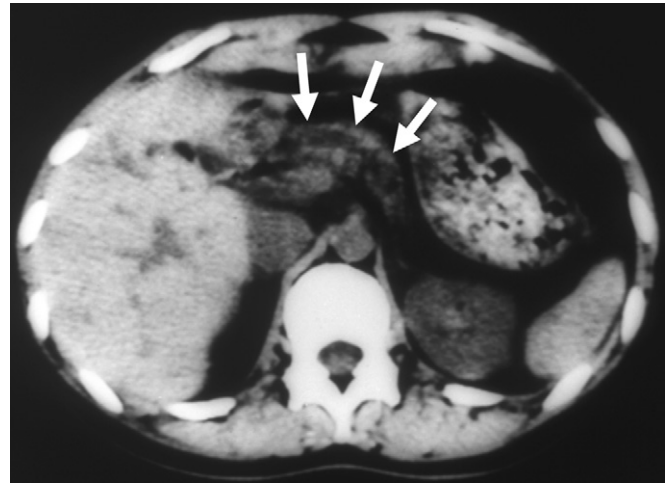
Computed tomographic scan of a patient with an irregularly dilated pancreatic duct (arrows). The patient underwent a longitudinal pancreaticojejunostomy (Puestow) procedure.
